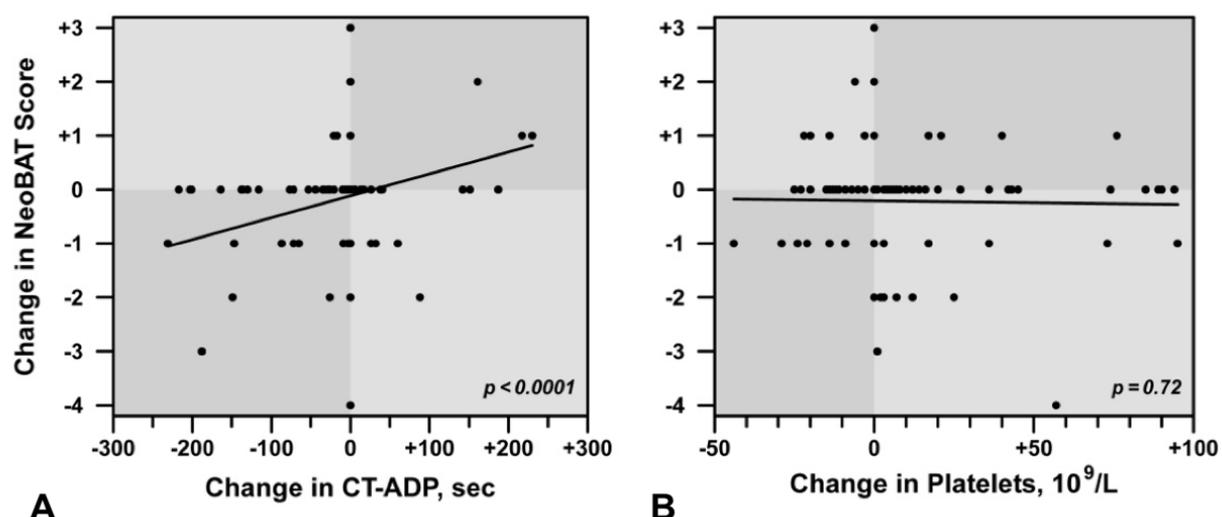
One-day change in NeoBAT score vs. change in CT-ADP (A) and vs. change in platelet count (B) in infants with gestational age < 27 weeks. The fitted line was generated from repeated-measures regression analysis.
